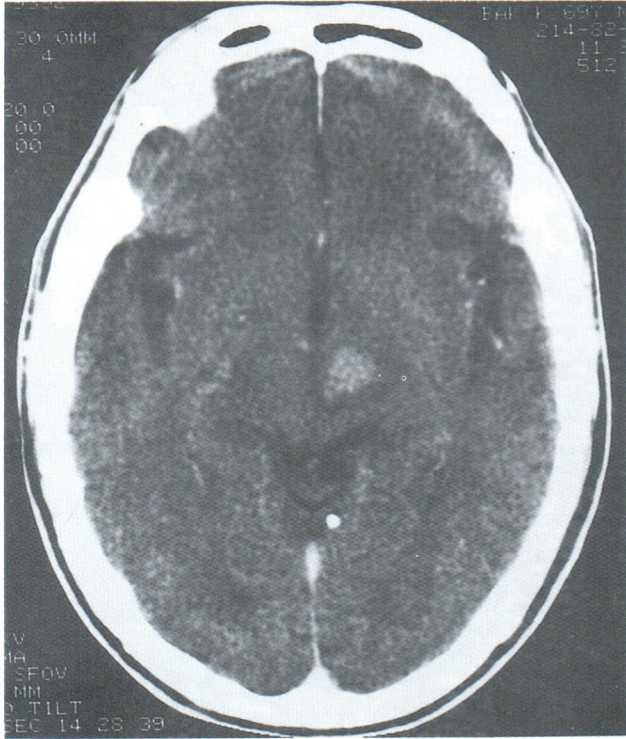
CT shows hematoma in the left mid brain
